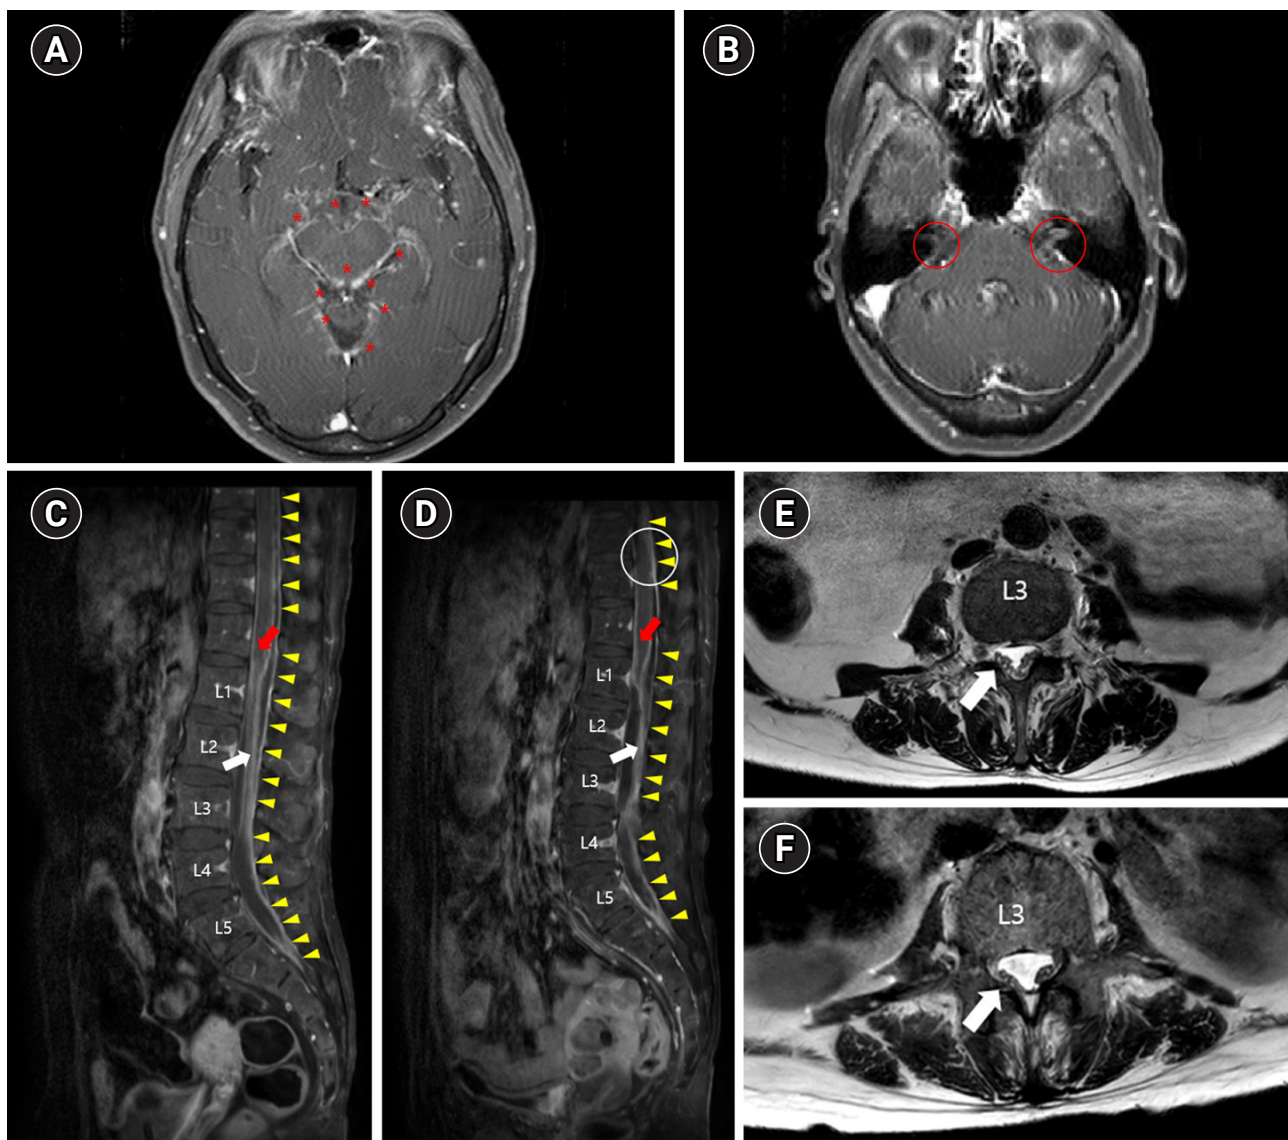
Brain (A, B) and spine (C, D, E, F) magnetic resonance imaging (MRI) of the patient. (A) Gadolinium-enhanced T1 axial view at the midbrain level. Asterisks (*) indicate small nodular enhancing foci of the diffusely enhanced meninx. (B) Gadolinium-enhanced T1 axial view at the pons level. Red circles indicate the right and left facial-vestibulocochlear nerve complexes with perineural enhancement. (C) Gadolinium-enhanced T1 sagittal view of the first spine MRI. The red arrow indicates conus medullaris with surface enhancement, and the white arrow indicates cauda equina with irregular leptomeningeal thickening and enhancement. Yellow arrowheads indicate dural enhancement along the spinal canal. (D) T2 axial view at the L3 level of the first spine MRI. The white arrow indicates the cauda equina with irregular leptomeningeal thickening and enhancement at the L3 level. (E) Gadolinium-enhanced T1 sagittal view of the follow-up spine MRI. Compared to the first spine MRI (C), the cauda equina (white arrow) is clumped and adherent to the dural sac, and obliteration of the subarachnoid space (white circle) was observed. (F) T2 axial view at the L3 level of the follow-up spine MRI. The white arrow indicates the cauda equina with more adhesion to the dural sac than the first spine MRI (D).
